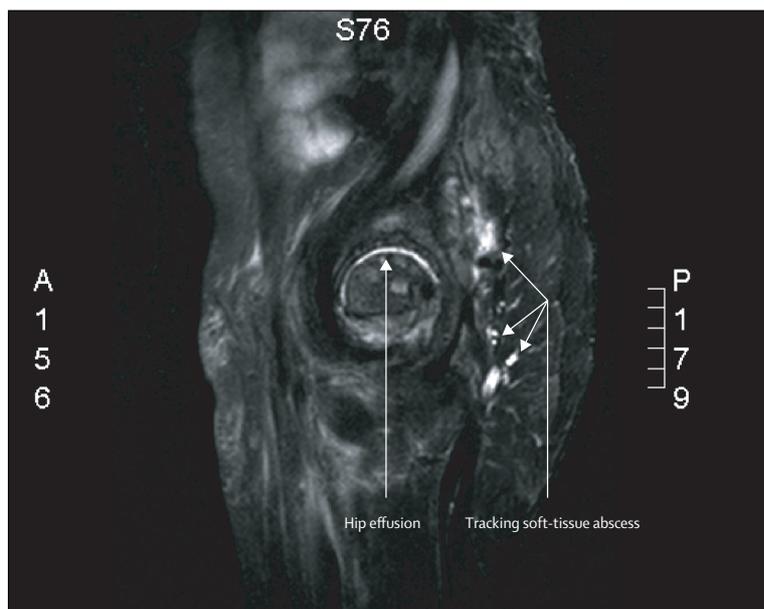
MRI of staphylococcal septic arthritis of left hip, with fluid collections between planes of gluteal muscles
